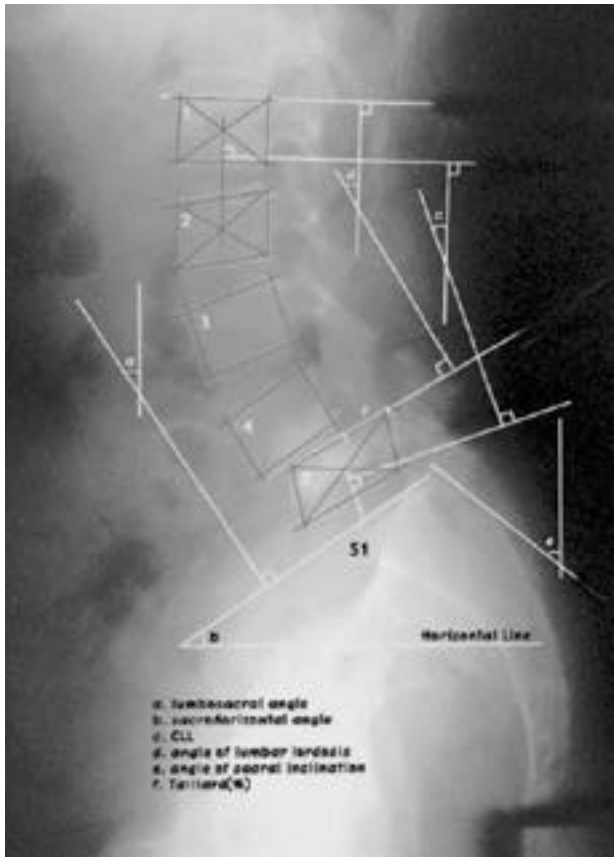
Parameters that represents the radiographic measurement of the lumbar spine. a. lumbosacral angle b. sacrohorizontal angle c. CLL d. angle of lumbar lordosis e. angle of sacral inclination f. Taillard(%)
